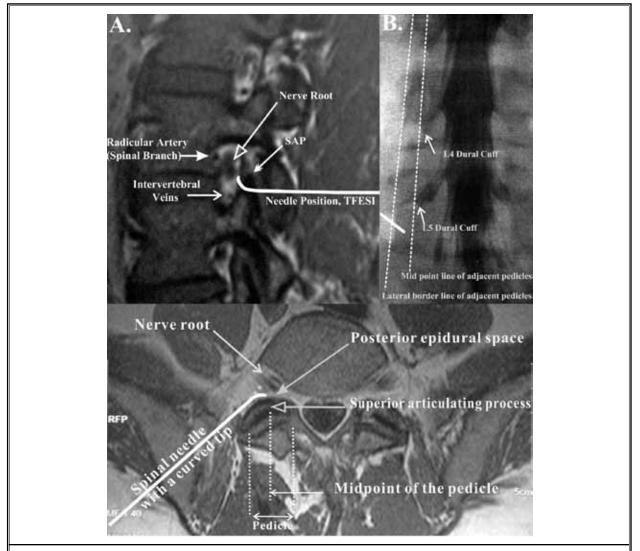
The final needle position at L5-S1 foramen for L5 TFESI. (A) Sagittal view of lumbar MRI. Needle: Radicular artery (or the branch of spinal artery) is commonly located superoanterior to the nerve root. White solid arrow: Radicular artery. (B) AP view of lumbar myelogram: The dural cuff may end medial to the midline of adjacent superior and inferior pedicles. (C) Axial view of lumbar MRI. The spinal needle tip wrapped around the SAP.
